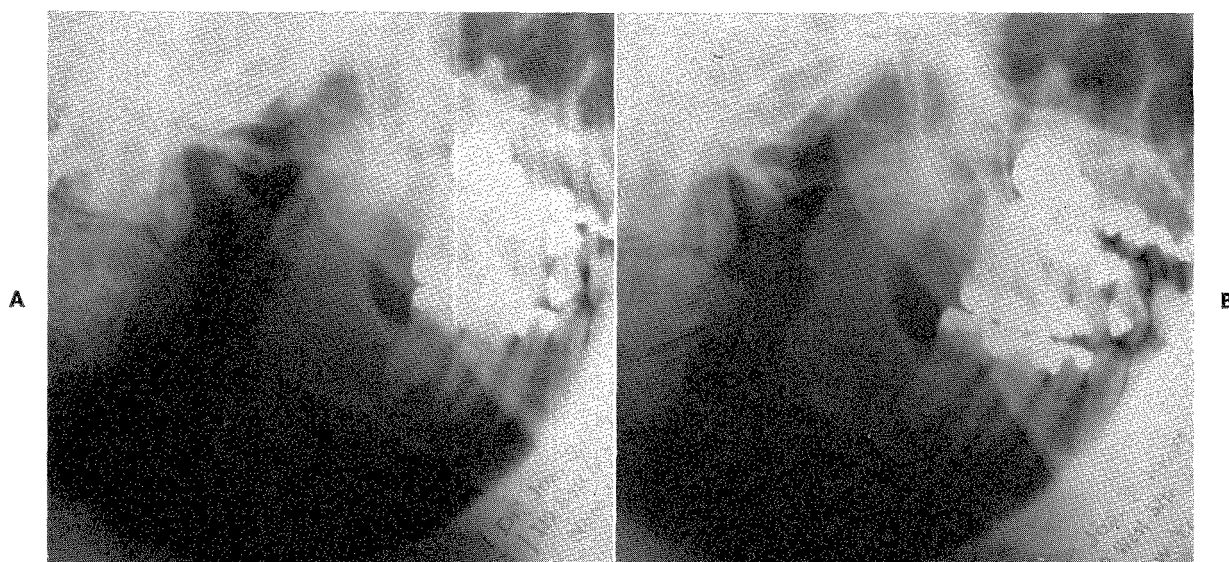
Roentgenograms of the right temporomandibular joint with the mandible (A) protruded and (B) retruded. The protruded position is a forced one. There is no evidence of a condyle. (Refer to the text.)
